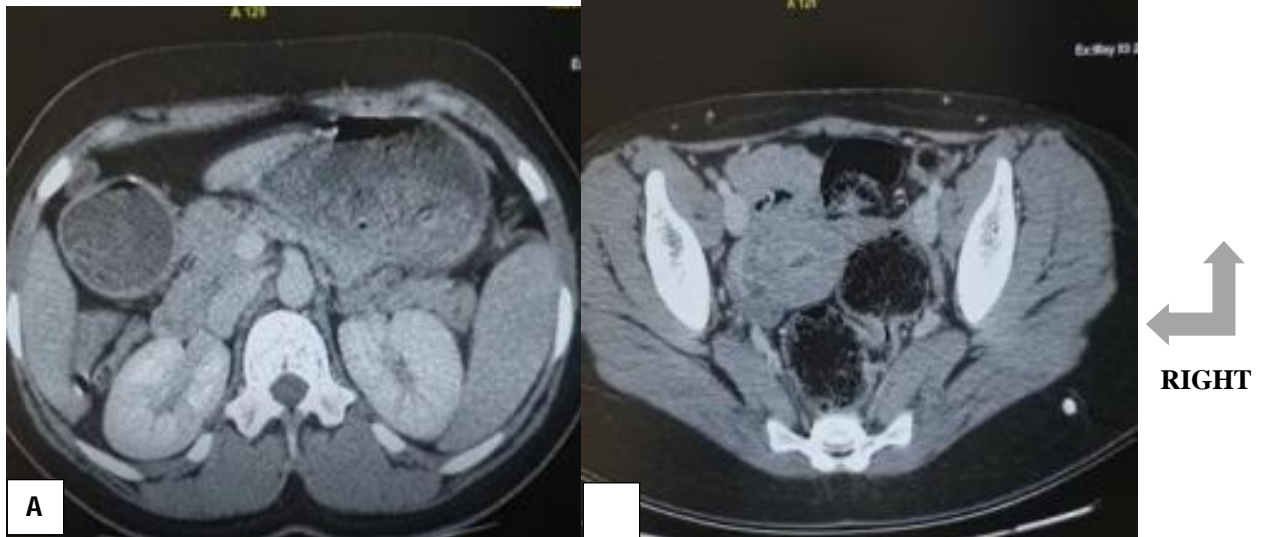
A.B. Axial CT slice post contrast passing through the plane of the inferior vena cava at the level of the kidneys: thrombosis of the right ovarian vein extended to its outlet at the level of the inferior vena cava appearing to be discreetly invaded. (blue Arrow)
